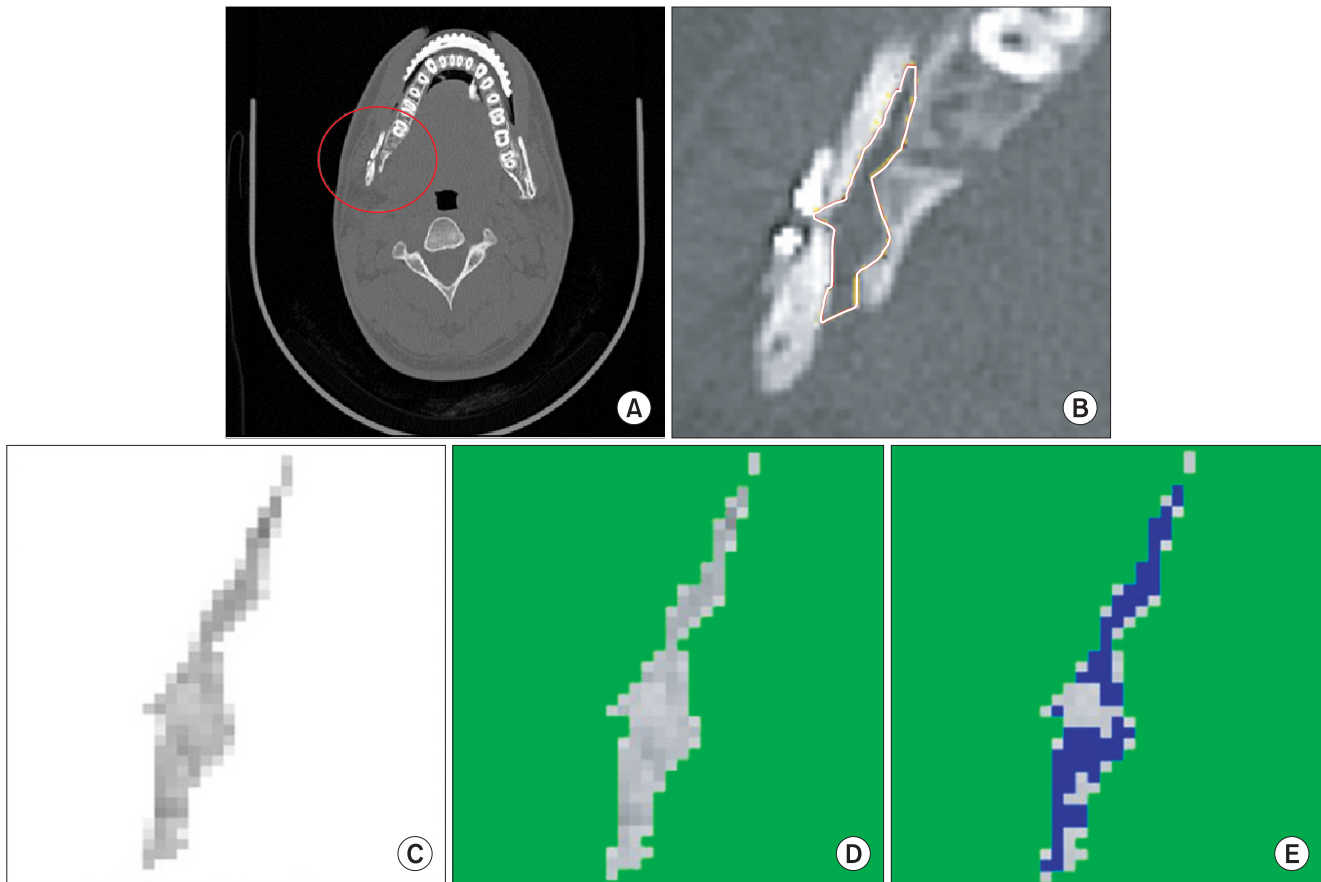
Evaluation of bone regeneration using Image J. A. The buccal fracture was occurred on right proximal segment (circle). B. The total inter-segmental area between the proximal and distal segments was defined based on the axial computed tomography image. C. The total inter-segmental area was adjusted to the threshold below 210 in the Image J program, where the threshold of cortical and medullar bone was greater than 210. D, E. The area of newly formed bone (threshold from 190 to 210 in the Image J program) was extracted from the total inter-segmental area. Soft tissue and dead space (threshold below 190) were also removed. Finally, the ratio of new bone area to total inter-segmental area was calculated.
